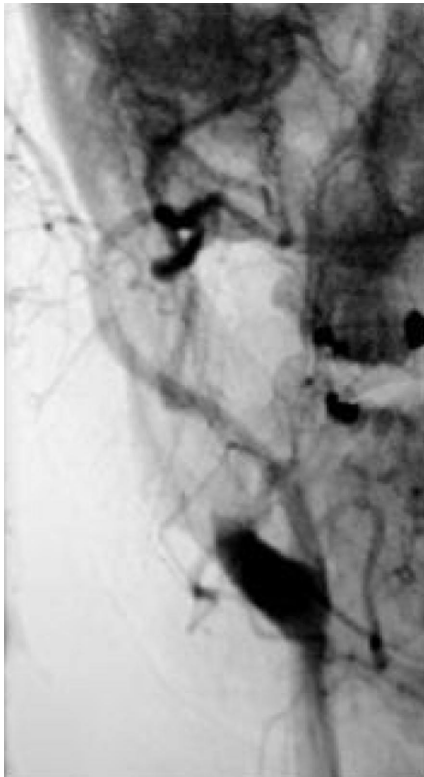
Catheter angiography shows an occlusion of the internal carotid artery about 2 cm after the origin and a small plaque at the medial wall of the carotid bifurcation. The cause of carotid occlusion was identified by magnetic resonance imaging, which demonstrated a dissection hematoma in the cervical segment of the occluded artery.
